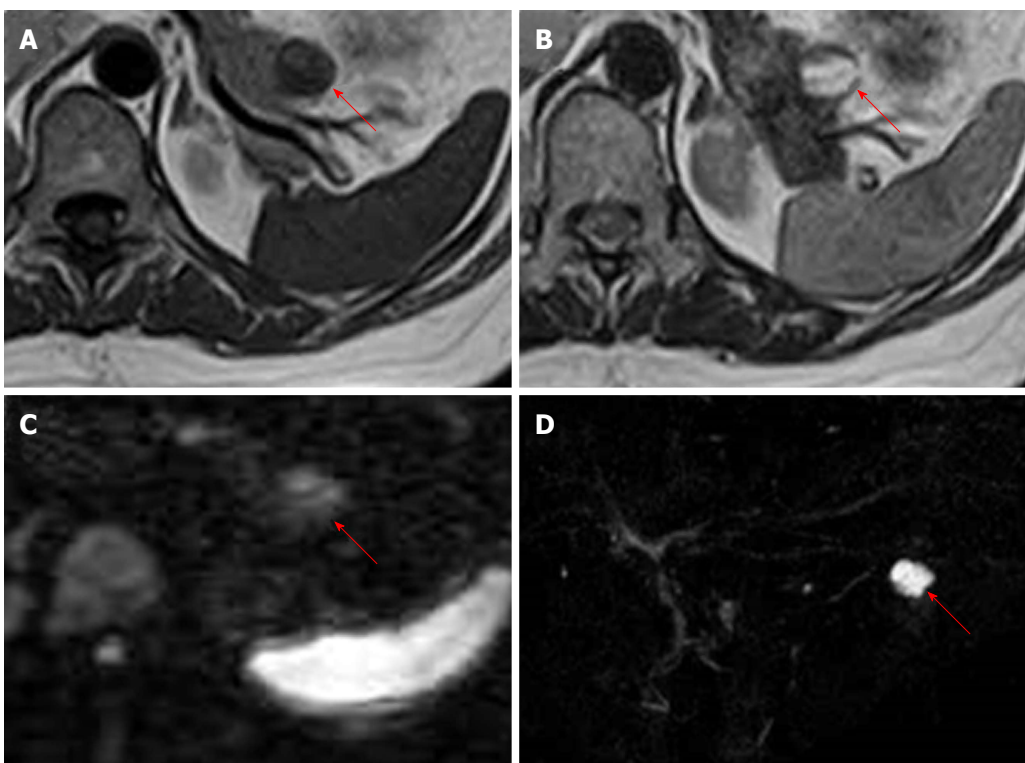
Findings from magnetic resonance imaging. A: The cystic lesion in the pancreatic tail (red arrow) appears hypointense and some areas appear relatively hyperintense compared to inside the cyst on T1-weighted images; B: The lesion (red arrow) appears mainly hyperintense, while the peripheral rim and nodule appear hypointense on T2-weighted images; C: The lesion (red arrow) appears relatively hyperintense on diffusion-weighted images; D: The lesion (red arrow) is not continuous with the main pancreatic duct on magnetic resonance cholangiopancreatography.
